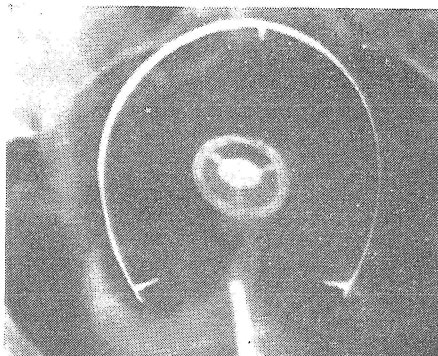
X-ray picture of the same uterus.
